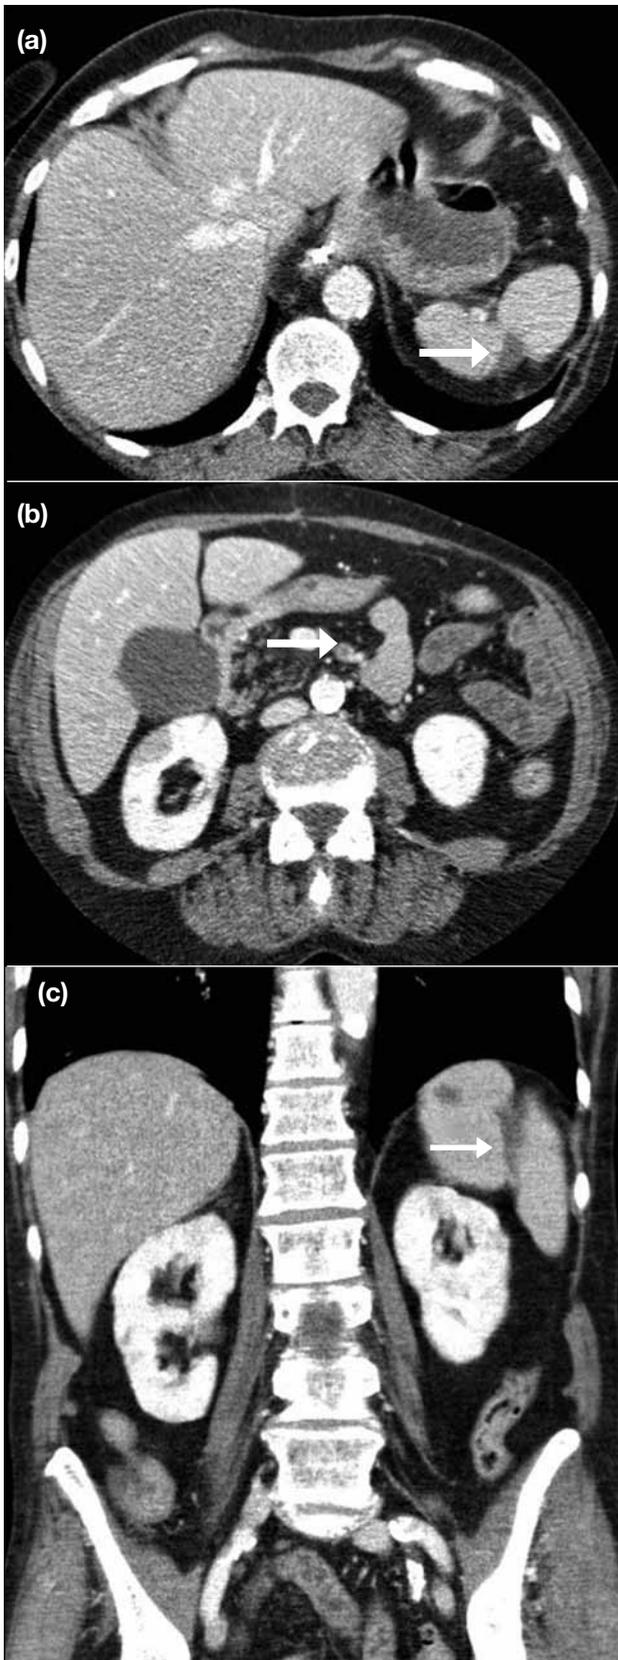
An 82-year-old female with arterial splenic infarct: (a, b) axial and (c) coronal reformats of computed tomography demonstrating wedge-shaped infarct of spleen with thrombus in superior mesenteric artery (arrows).
